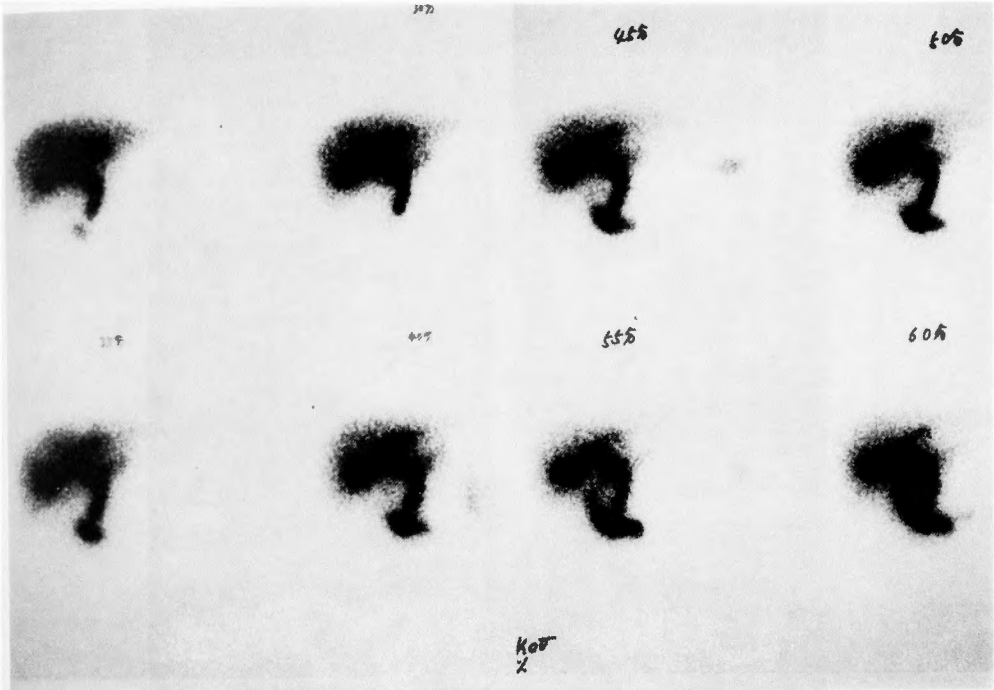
Hepatobiliary scintigram using $^{99m}\text{TcPI}$ suggests bile stasis
